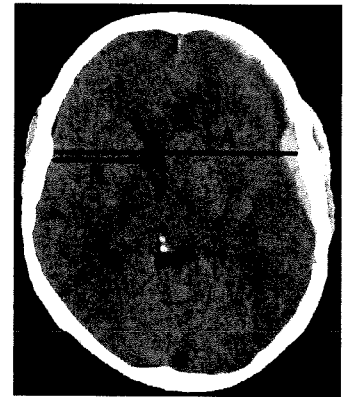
Assessment of midline shift on computed tomographic scan.
